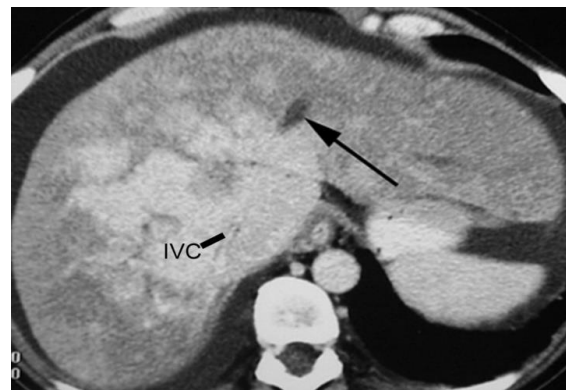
CT scan image of hepatobiliary system
